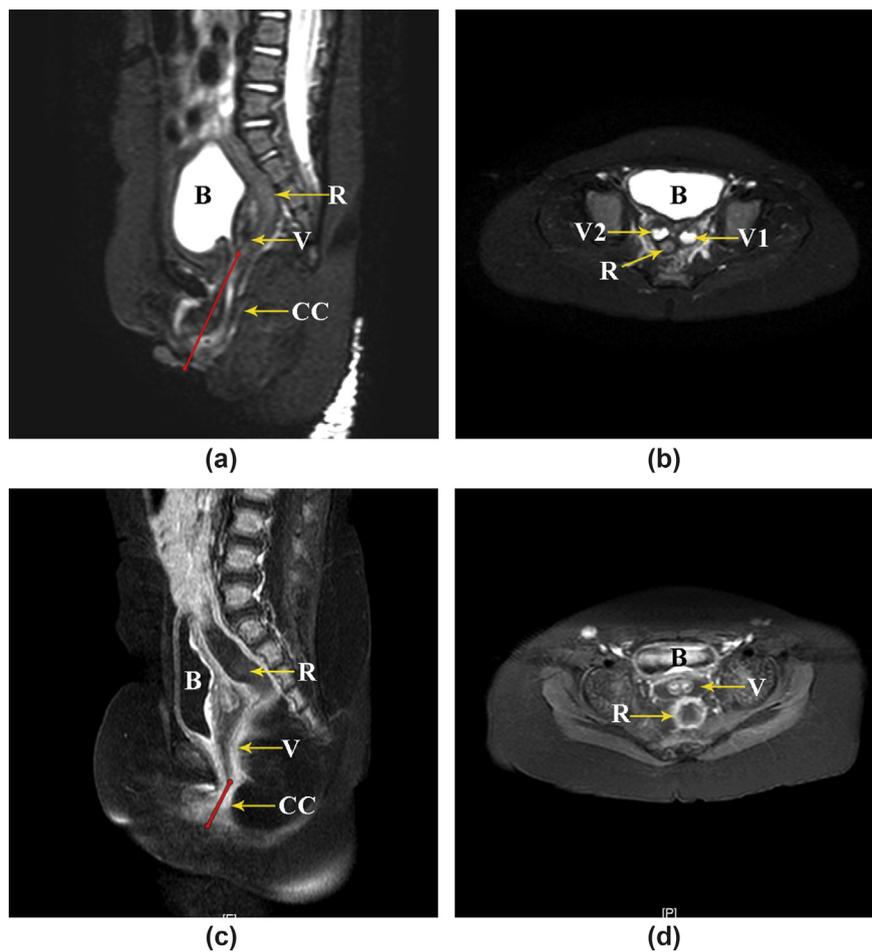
(a,b) Case 25: a patient aged 13 months with PC. (a) Mid-sagittal MRI displayed that the urethra, vagina (V), and rectum fistula (R) had merged into a long CC. The yellow line indicates the measurement land marker of CC. (b) Axial MRI of the same patient showing the duplicated vagina (V), rectum fistula (R) ended in between two vaginas. (c,d) Case 26: a patient aged 16 months with PC. (c) Mid-sagittal MRI showed the patient had hydrocolpos (V) and a short CC. (d) Axial MRI of the same patient showing that there were two cervixes in the vagina (V).
